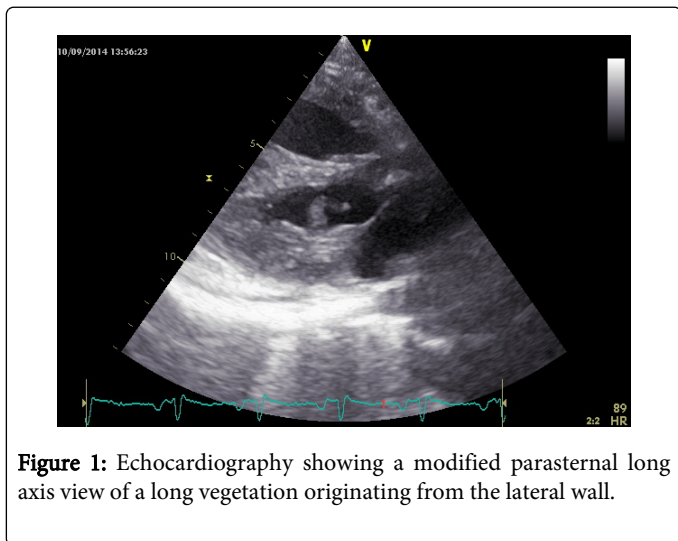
Echocardiography showing a modified parasternal long axis view of a long vegetation originating from the lateral wall.
